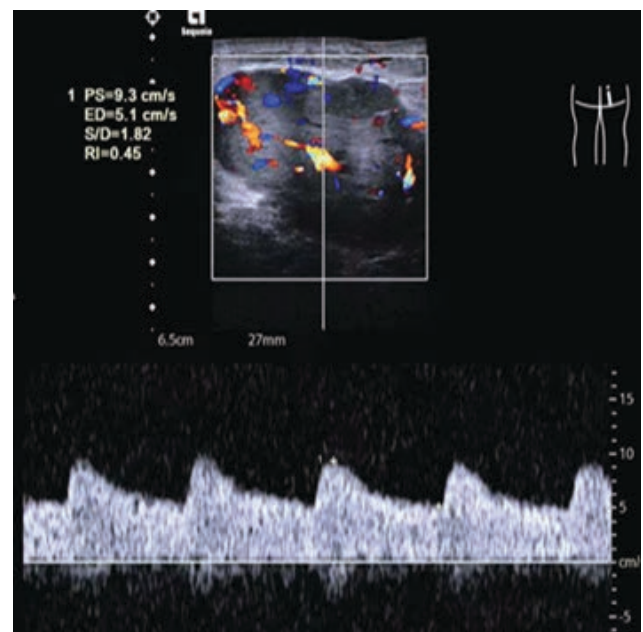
Ultrasonic blood flow spectrum.
